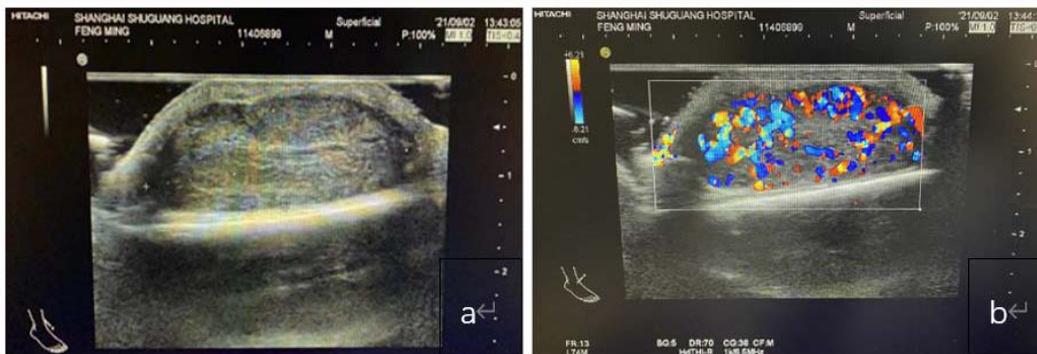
The ultrasonic image and hemodynamic boundary of the patient's skin lesions are clear, the shape is regular, and there are abundant blood flow signals.
